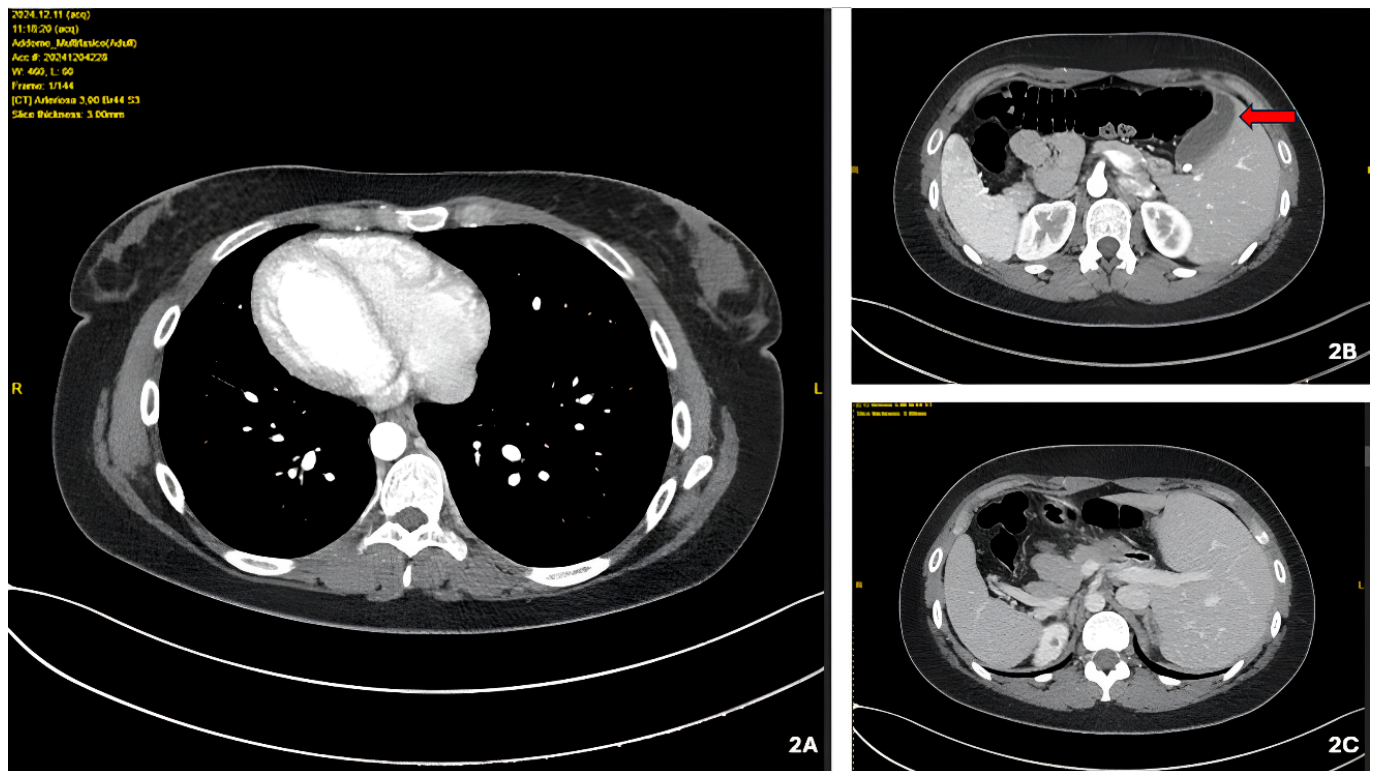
Preoperative computed axial tomography (CT) (2A) Note the dextrocardia; (2B) the red arrow indicates the gallbladder in left abdominal position; (2C) position of abdominal organs and vessels in mirrored anatomical position. The overall morphological picture, thoracic and abdominal, reflects SVI totalis.
